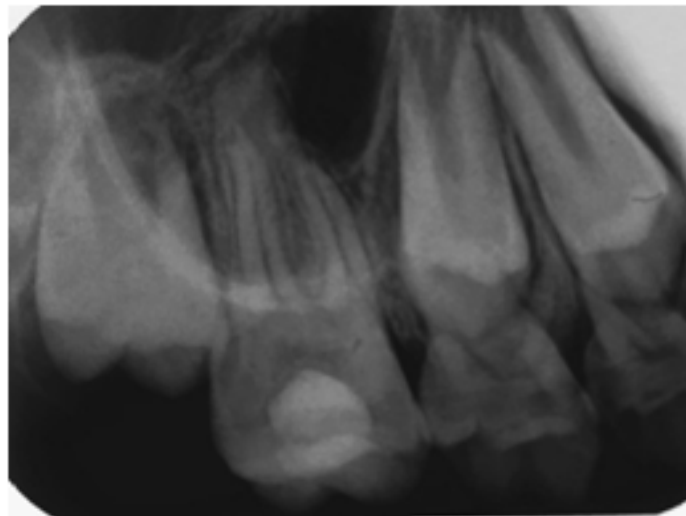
15 month follow-up Radiograph
